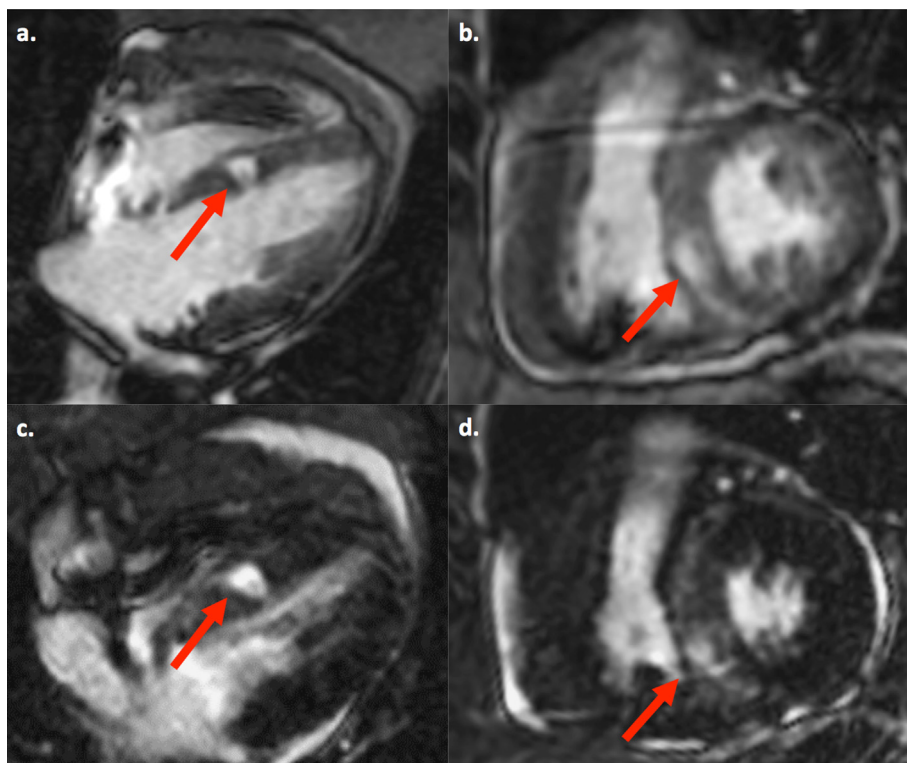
Cardiac magnetic resonance imaging (MRI) in axial and sagittal view at 3 months (a, b) and 6 months (c, d) confirming the size reduction of the lesion and the emergence of a patch of edema on the 6-month images (c, d).
